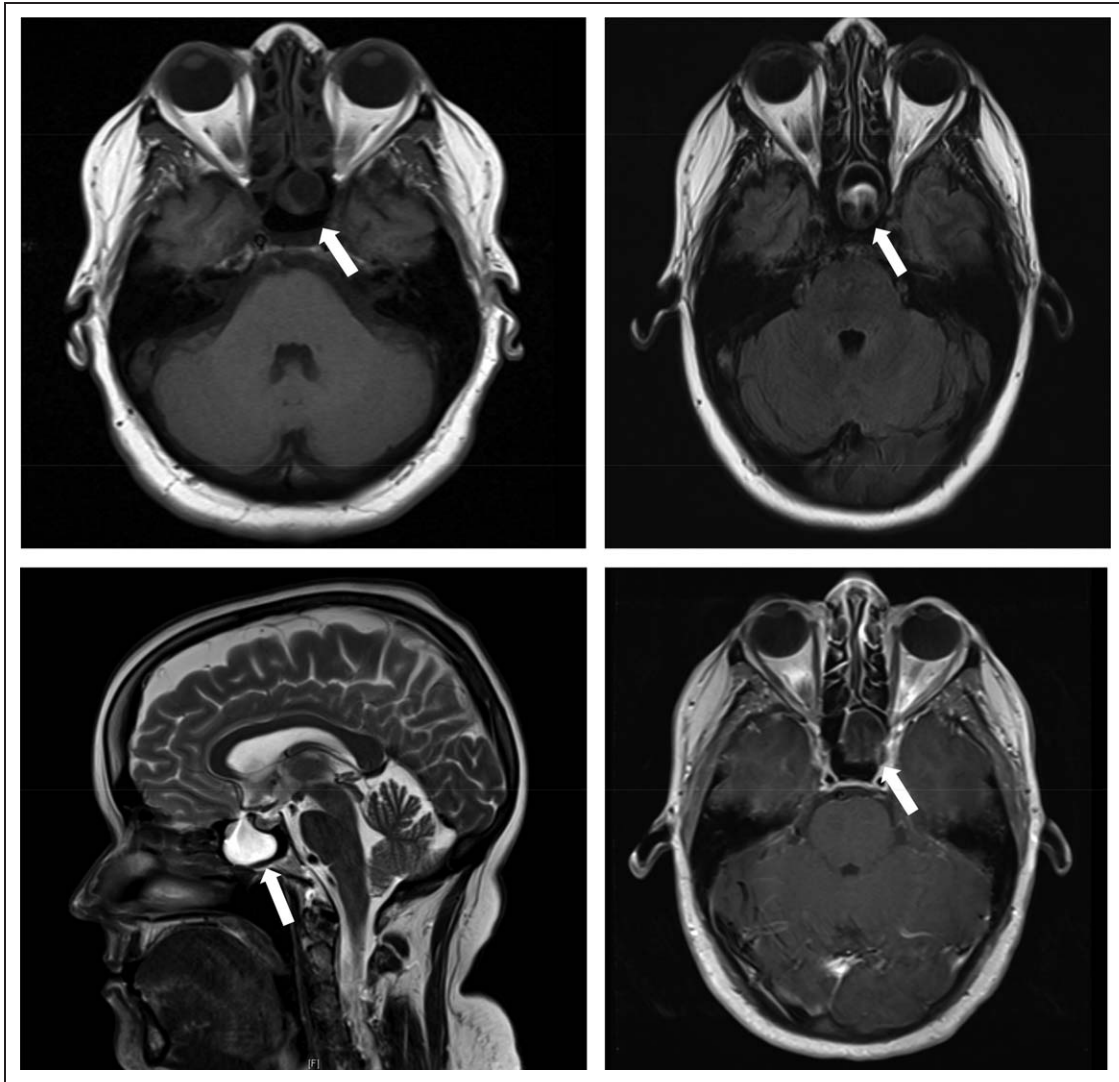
Brain MRI. (Top left) Axial T1 image from MRI performed 2 years prior to presentation. Initially read as a mucous retention cyst (arrow). (Top right) Axial FLAIR obtained after presentation. Gray matter soft tissue can be seen protruding into the posterior aspect of the herniation (arrow). (Bottom left) Sagittal T2-weighted image reveals a sphenoid sinus meningoencephalocele (arrow). (Bottom right) Axial T1 contrasted image. Gray matter soft tissue is again noted within the sphenoid cavity (arrow).
